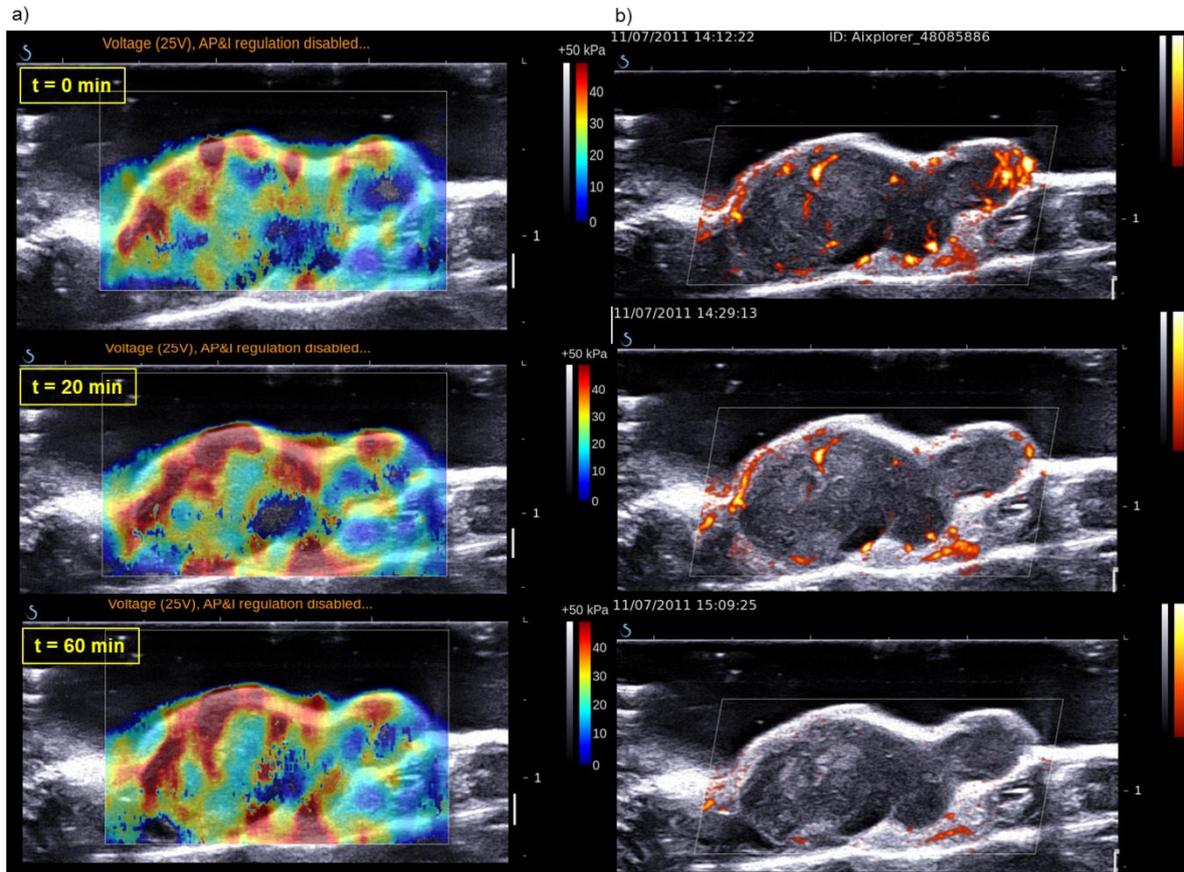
Evolution of the tumour elasticity and of the vascular network after the antivasular injection took place on the 12th day for a representative ectopic tumour. The shear wave and the blood velocity were color-coded in scales ranging from 0 to 50 kPa and 0 to 2 m/s respectively. (a) The tumour global elasticity remained almost constant throughout the experience, with no significant changes between $t=0$ and $t=60$ minutes; (b) The Doppler images show how the tumour blood vessels were attacked by the drug, cutting the blood flood within some minutes after the injection.
